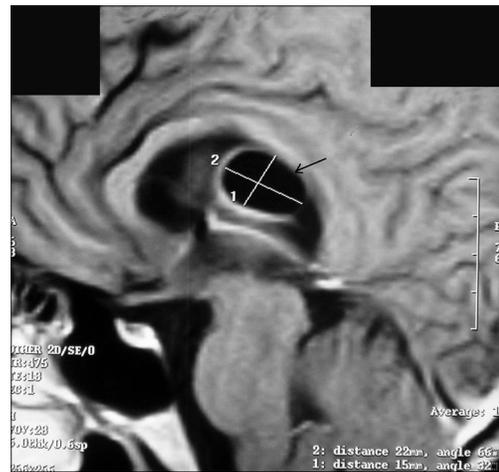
MRI sagittal section shows well-defined hypointense lesion in lateral ventricle (arrow)
